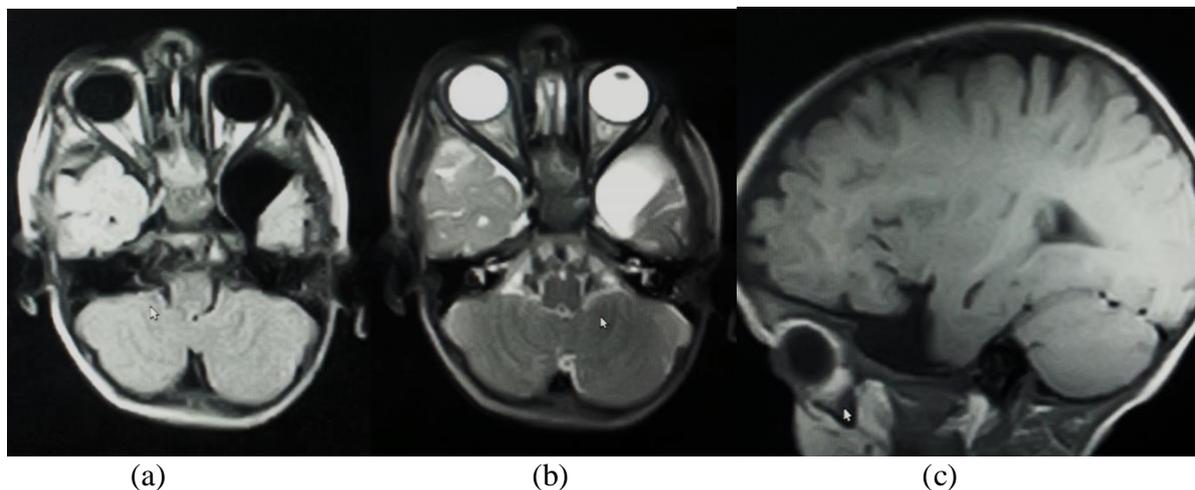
A 6- year- old male presented with hyperactivity and abnormal movement. a) Axial FLAIR showed widened left temporal arachnoid space with relative reduction in the size of left temporal lobe. b) Axial T2 showed high SCF of the cyst. c) Sagittal T1 showed the relative reduction of the left temporal lobe size (Final diagnosis left temporal lobe arachnoid cyst).
